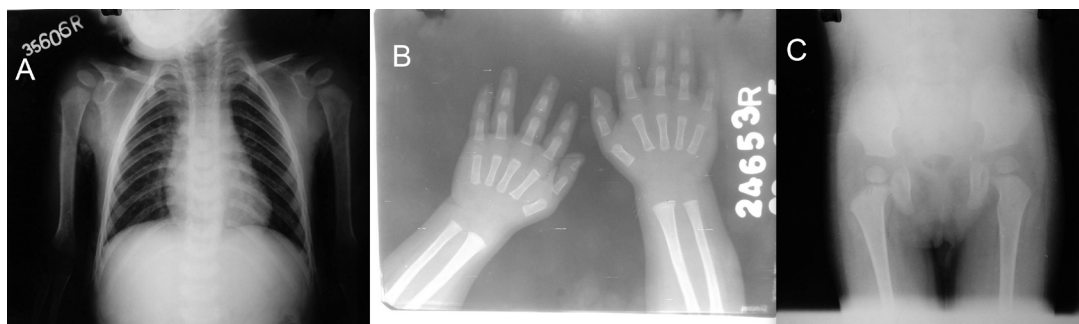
Radiographs showing skeletal abnormalities (A), Chest radiograph shows hypoplastic clavicles bilaterally. (B), Absence of carpal bones seen on hand wrist x-ray. (C), Pelvic abnormalities seen on radiograph.
